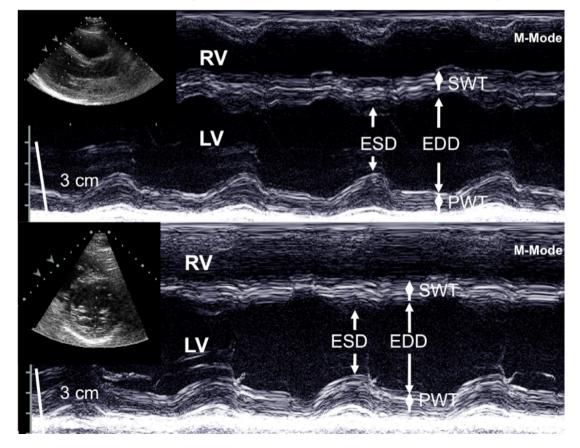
Calculation of left ventricular mass. Depicted are measurements of left ventricular (LV) end-diastolic diameter (EDD) and end-systolic diameter (ESD) on M-mode and B-mode pictures either guided by a parasternal short axis (PSX) or a long axis (PLX) image. In all pictures septal wall thickness (SWT) and posterior wall thickness (PWT) present end-diastolic extension. The original tracing is from the InGenious HyperCare participant A2100453103.
